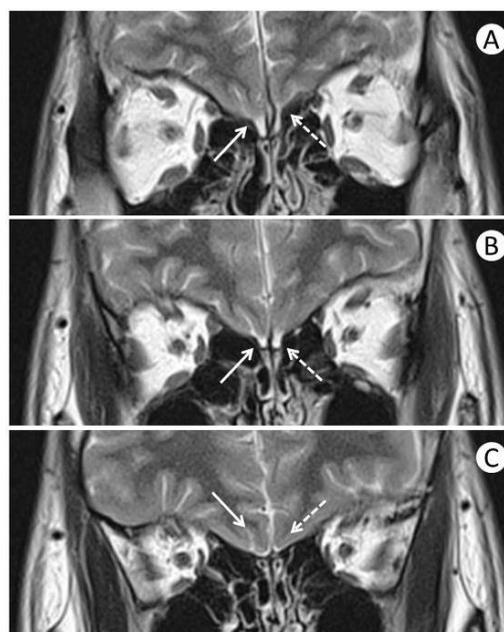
Coronal T2-weighted MRI shows absence of the olfactory bulbs (A, B) and decreased olfactory sulci (C)
